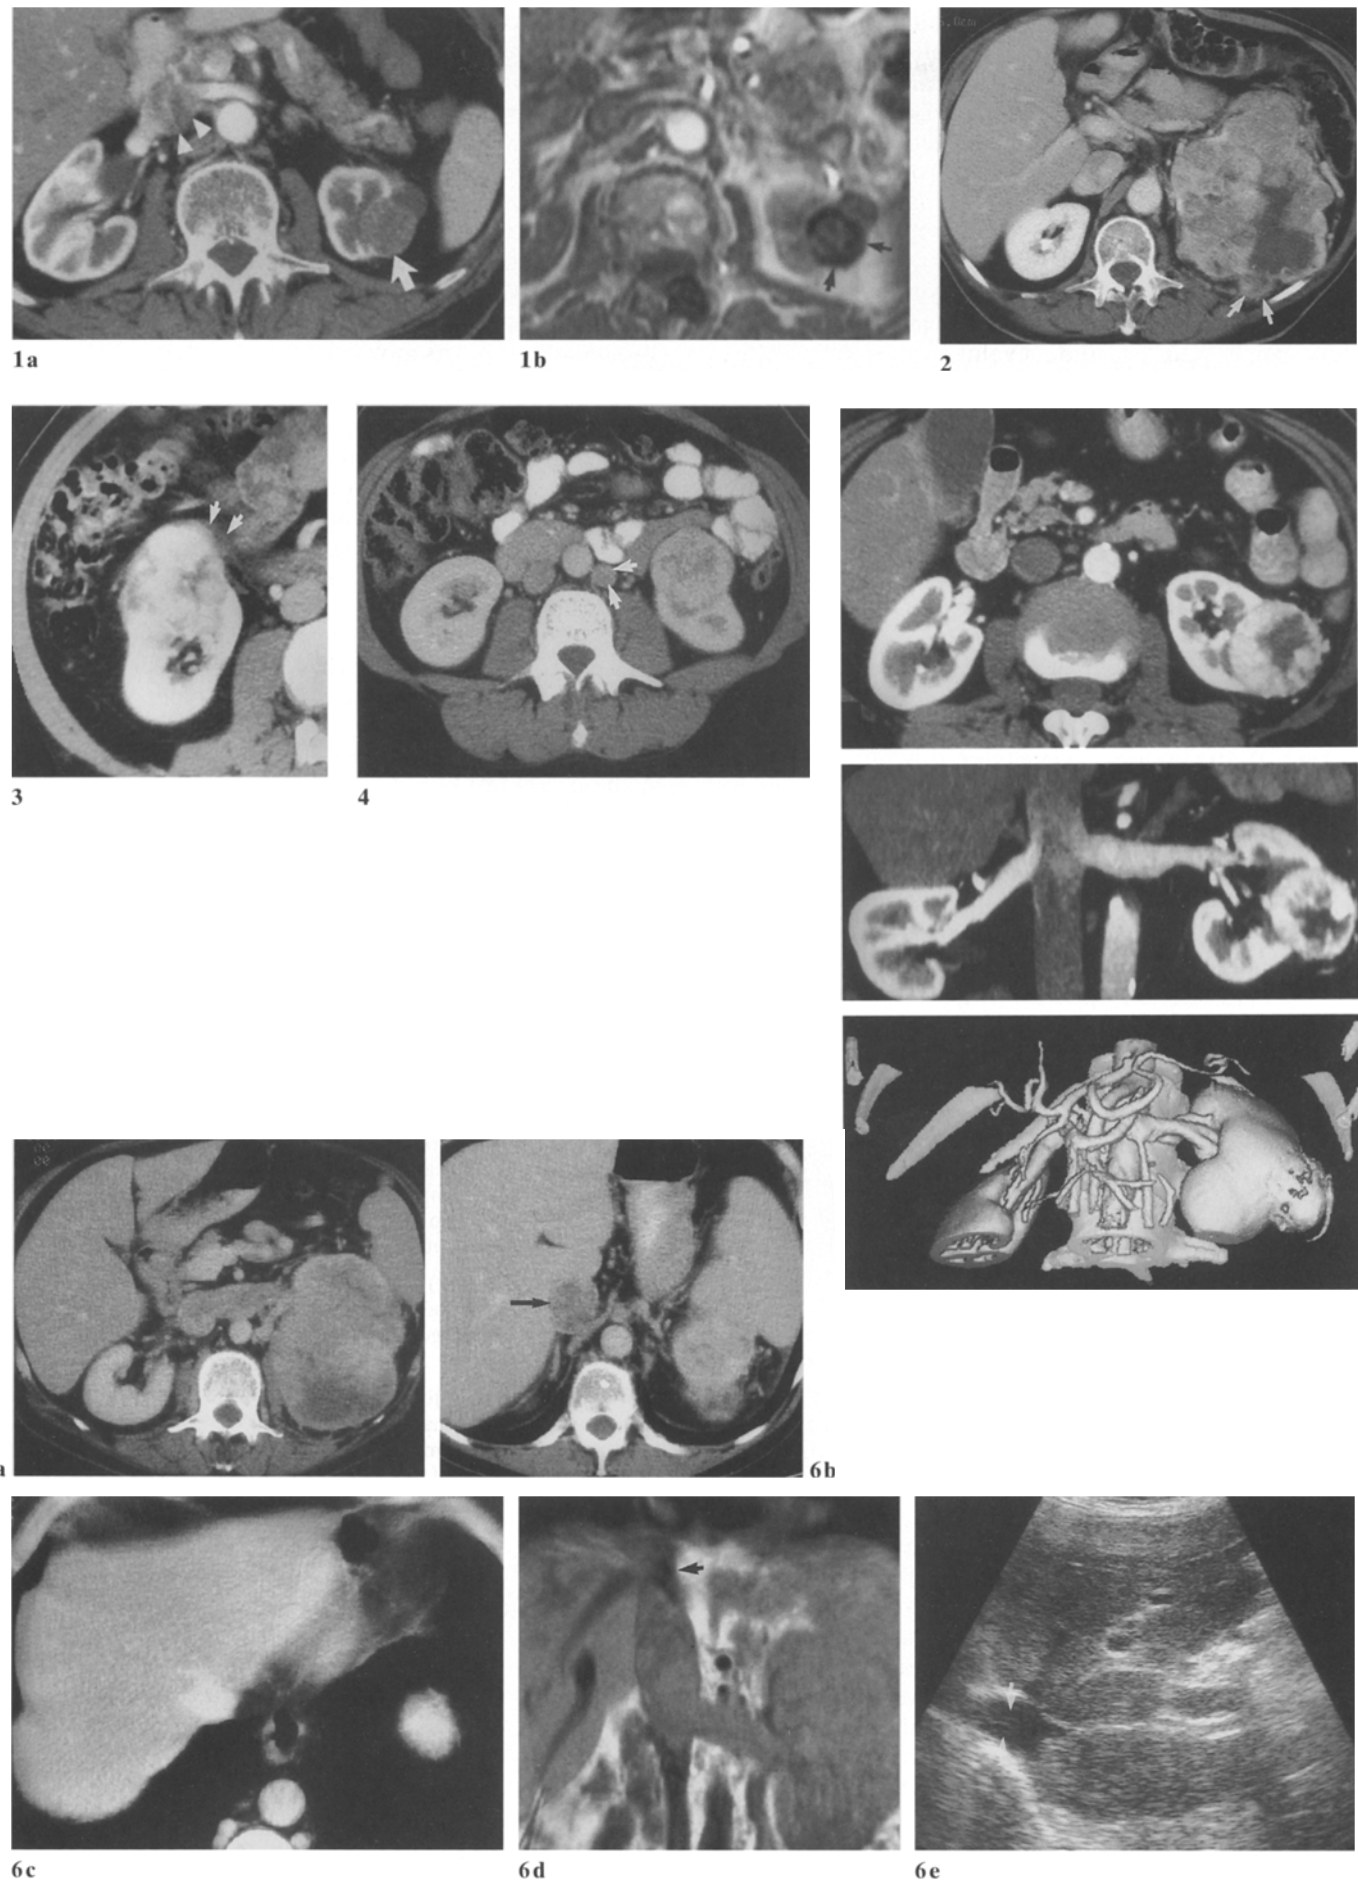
Stage II (T3a) renal cell carcinoma. CT scan in a patient with renal cell carcinoma demonstrating definite spread into the perirenal space by showing a discrete 1 cm mass extending into the perirenal space (*arrows*)
